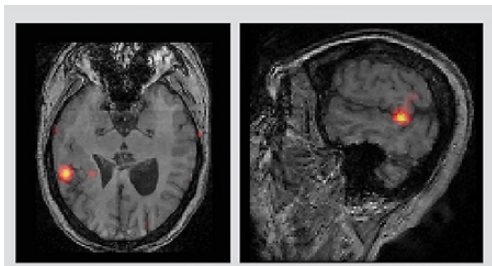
Subtraction ictal SPECT coregistered to MRI images pinpoint seizure focus.
